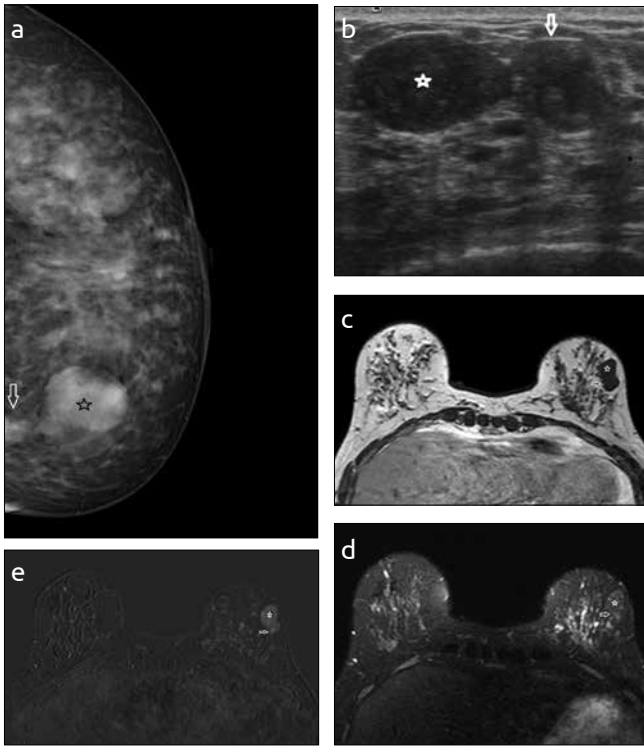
a-e (mass 12). A 48-years-old woman with tubular carcinoma. Craniocaudal mammography (a) shows high-density oval mass with indistinct margins (arrow) adjacent to fibroadenoma (asterisk) on outer quadrant of left breast. Tubular cancer cannot be seen on mediolateral oblique projection. Sonographically, irregular shaped, heterogeneous, microlobulated tubular carcinoma with posterior shadowing (arrow) and oval shaped hypoechoic fibroadenoma with well-defined margins (asterisk) were detected (b). Also a thin fat plane was seen between masses. Axial T1-weighted without fat suppression (c) and T2-weighted with fat suppression (d) images show 5mm hypointense tubular carcinoma (arrow) and fibroadenoma (asterisk). TC (arrow) shows heterogeneous contrast enhancement on T1-weighted gadolinium-enhanced subtraction image (2.second) (e)
